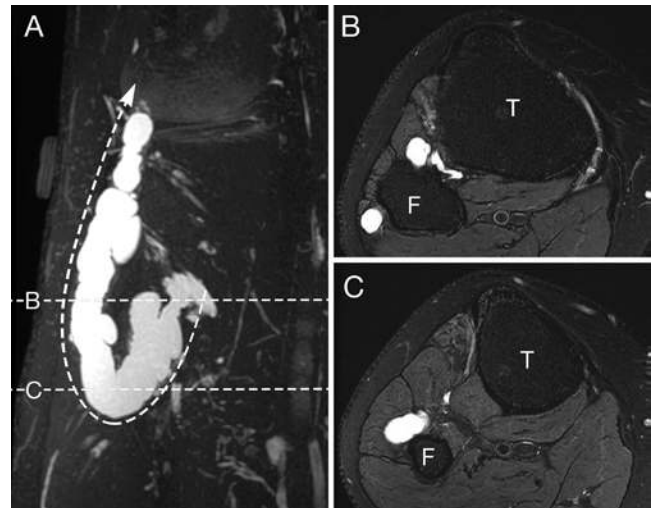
Typical example of a peroneal intraneural ganglion cyst with a connection to the STFJ (unpublished case, not included in this analysis). The coronal maximum intensity projection MR image from a T2-weighted fat-saturated sequence (A) demonstrates the classic “U” pattern in a peroneal intraneural ganglion cyst arising from the STFJ (dashed arrow). The axial T2-weighted fat-saturated MR image through the level of the fibular head (B) demonstrates cyst within the common peroneal nerve (signet ring sign). There is intraneural cyst near the STFJ and joint fluid in the joint itself.¹⁴⁶ The axial T2-weighted fat-saturated image through the level of the fibular neck (C) demonstrates intraneural cyst within the articular branch (transverse limb sign). F = fibula; T = tibia.
